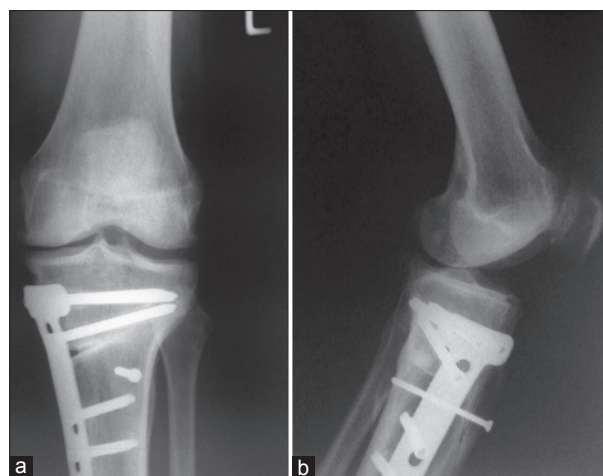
Anteroposterior (a) and lateral (b) nonweight bearing radiograph of the left knee after proximal high tibial osteotomy
